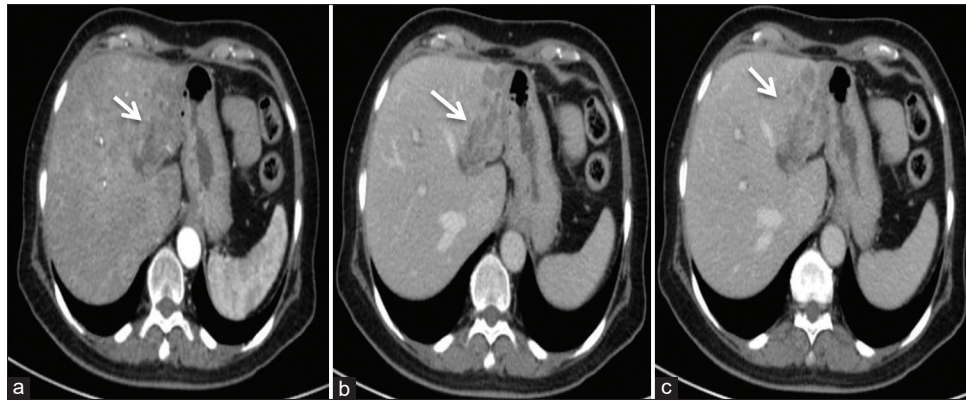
Contrast enhanced abdominal computed tomography scan in axial planes revealing left liver lobe biliary ectasia with an infiltrative soft tissue density within intrahepatic biliary ducts showing hypodensity in arterial phase (a) and also in portal (b) and delay phase (c) in comparison to liver parenchyma, note delay enhancement of lesion in comparison to early phase
